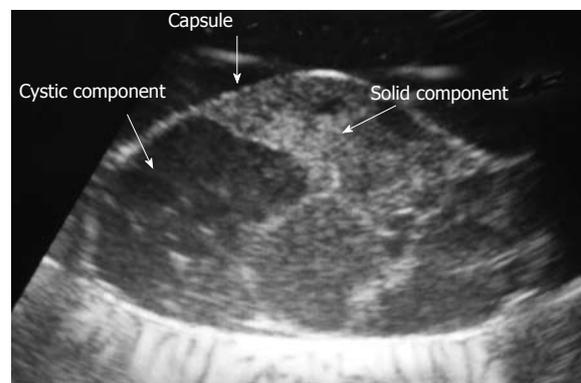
Intraoperative ultrasound showing the well-encapsulated pancreatic mass that is composed of solid and cystic components.
